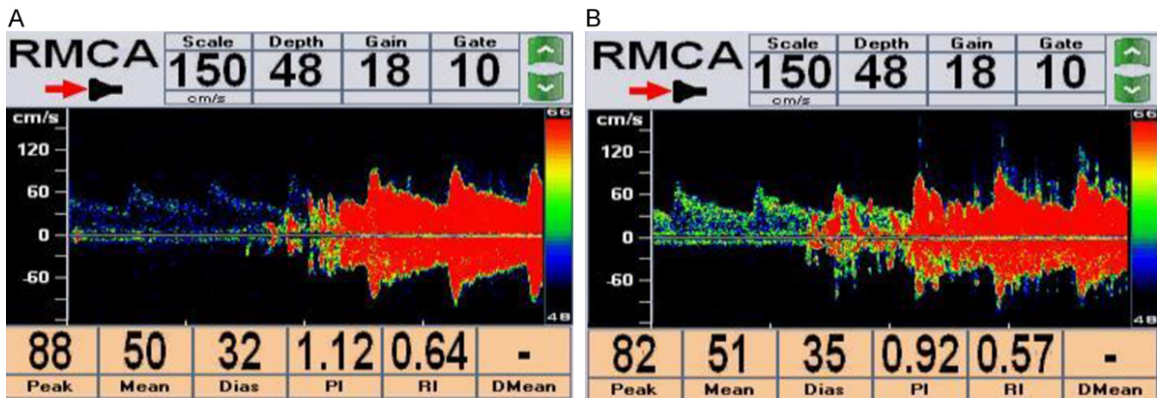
Contrast transcranial Doppler (cTCD) revealed a five-degree right-to-left shunt during both rest (A) and the Valsalva manoeuvre (B).
